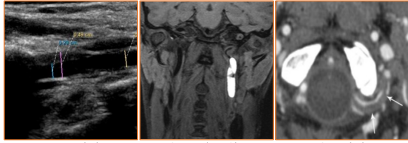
Vertebral artery dissection on ultrasound.
